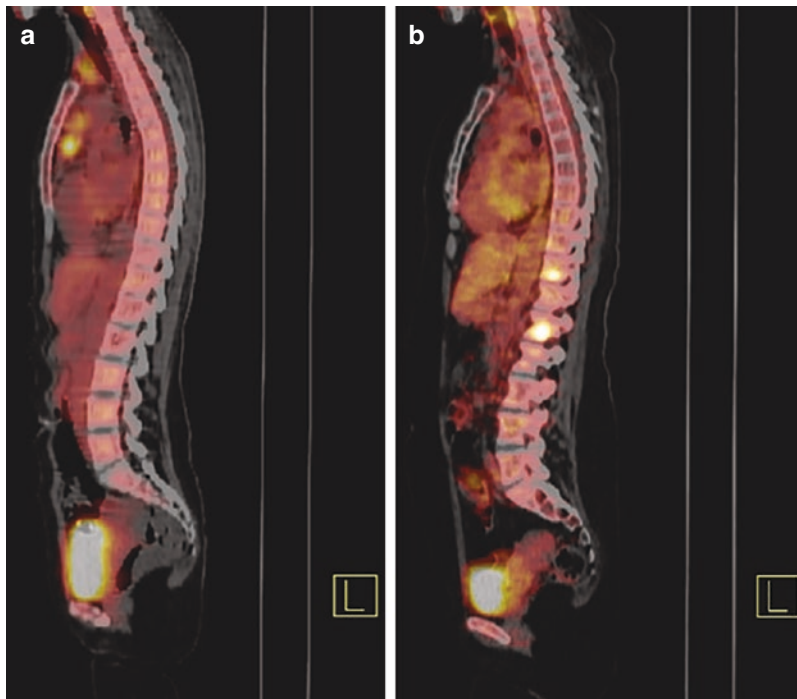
(a) Baseline staging in a patient with Hodgkin lymphoma. Intense FDG uptake is shown in a bulky mediastinal mass. Right cervical and right epiphrenic nodal involvement is also shown. (b) Post chemotherapy evaluation revealed a residual mediastinal abnormality with FDG uptake higher than the mediastinal blood pool but
